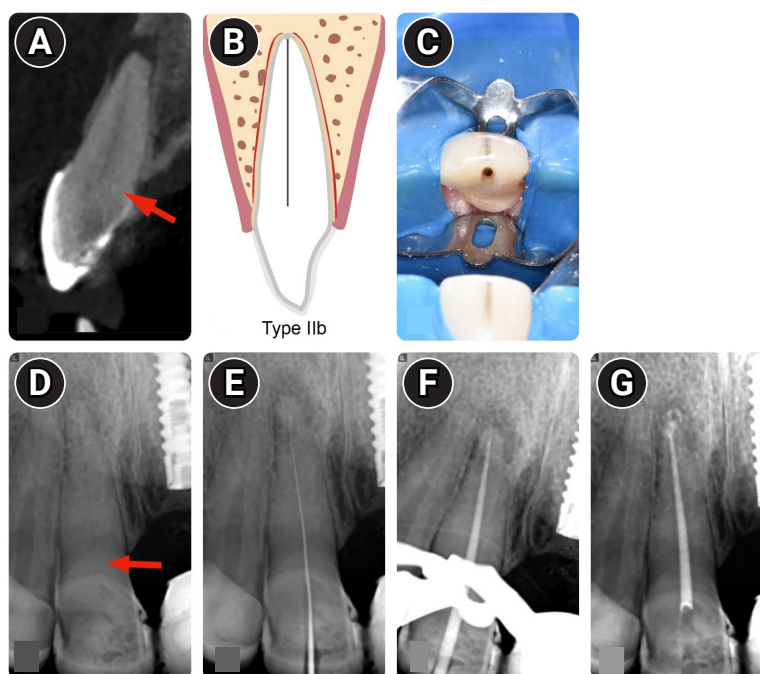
Characteristics of Type IIb root canal classification. (A) Tomographic image. The red arrow indicates the start of the canal lumen (target point). (B) Type IIb classification scheme. (C) Access to pulp chamber/root canal. (D) Initial radiograph. The red arrow indicates the start of the root canal. (E) Initial root canal negotiation with a file to determine the temporary working length. (F) Gutta-percha master point fitting before root canal filling. (G) Filled canal.
